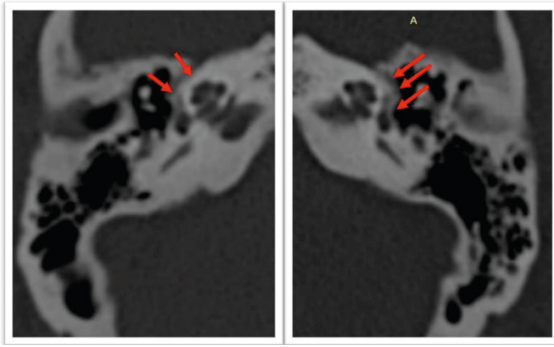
Axial CT images of the temporal bones with grade 3 otosclerosis in a 35-year-old patient demonstrated severe otosclerosis, with significant reduction in bone density around the cochlea (red arrows).
